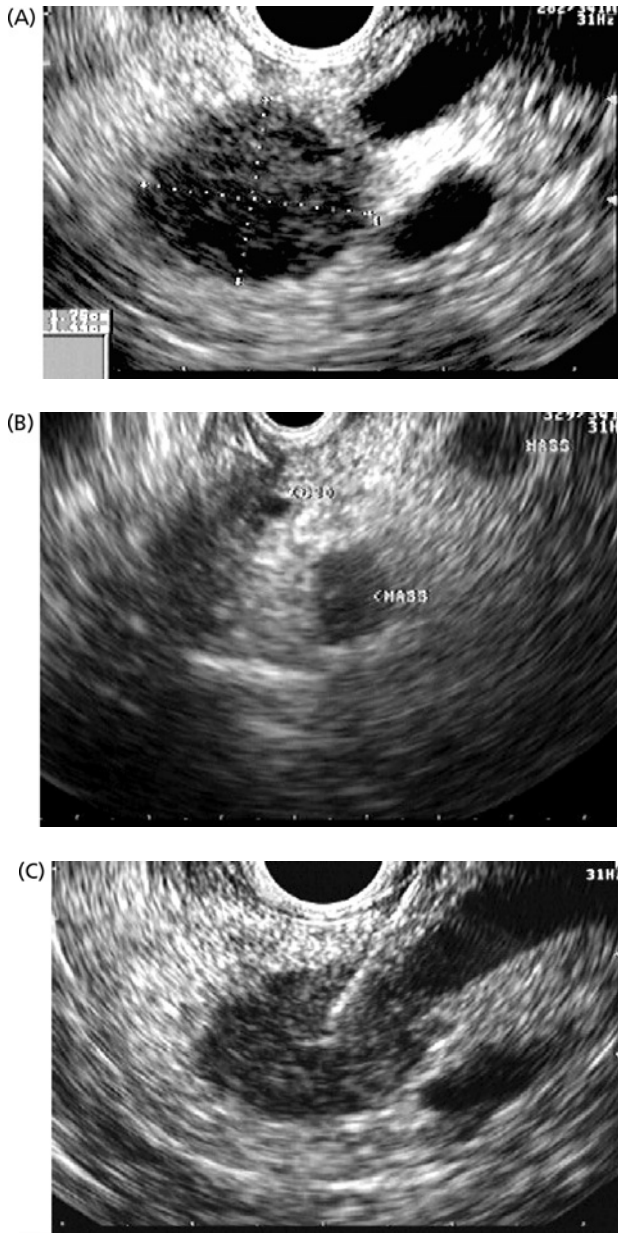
Metastatic renal cell carcinoma to the pancreas. (A) A large mass was identified in the pancreatic body on CT in this patient with abdominal pain. There was a remote history of renal cell carcinoma approximately 7 years earlier. EUS biopsy was requested to determine whether this was of primary pancreatic origin. (B) EUS demonstrated two additional focal masses in the pancreatic head which were not seen on CT. (C) Needle aspiration was performed and documented metastatic renal cell carcinoma.
